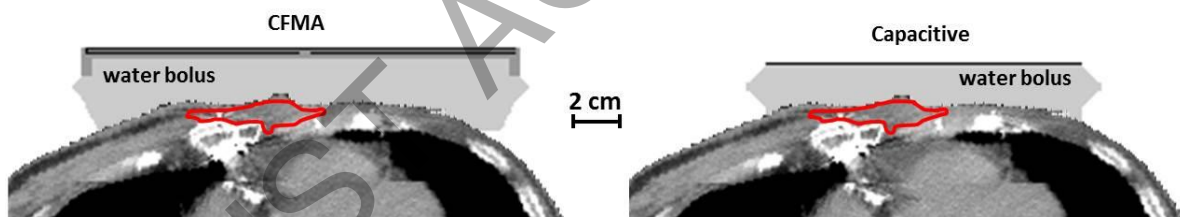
CT scan with the position of the modelled CFMA and capacitive antennas, for a recurrent breast cancer patient model. The red contour represents the target delineation.
